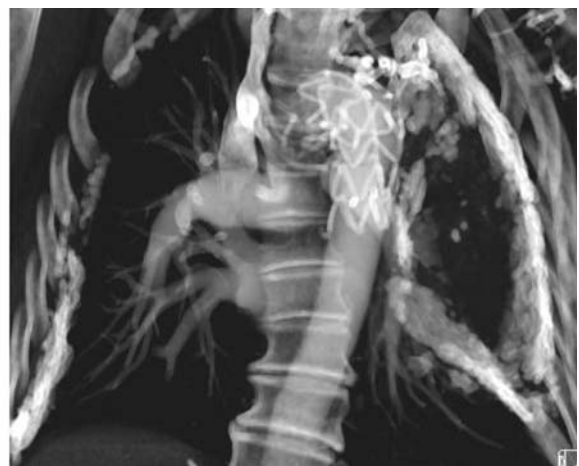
Postoperative computed tomography scan with perfect exclusion of the tuberculosis aneurysm
